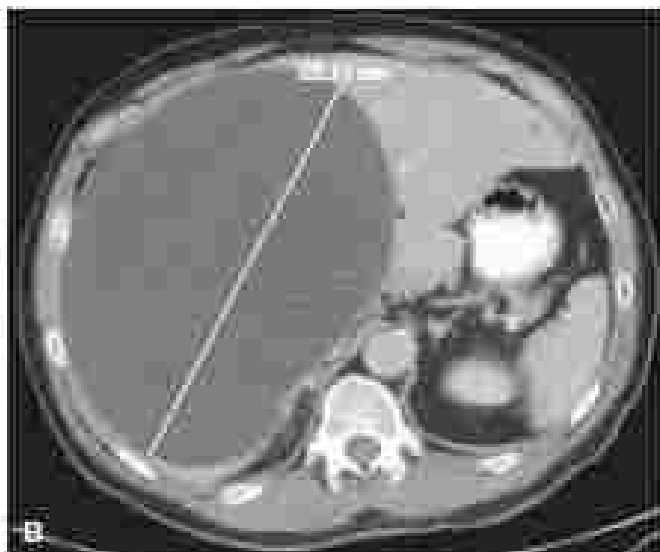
(A) Unenhanced image findings demonstrate simple liver cysts. (B) Axial CT scan shows a large, well-defined, hypodense cystic lesion in the liver, consistent with a simple liver cyst.
